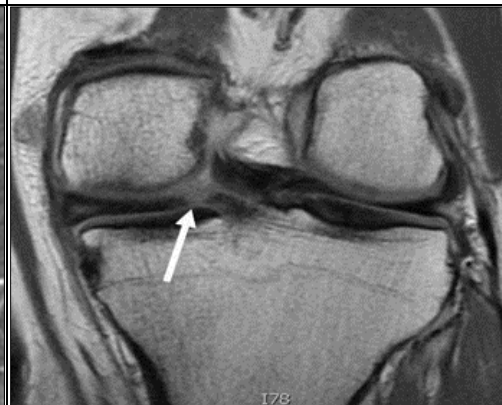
MRI T₁ weighted coronal image showing root tear in posterior horn of medial meniscus in another patient. The meniscus has torn off its attachment site and tends to subluxate posteromedially.
